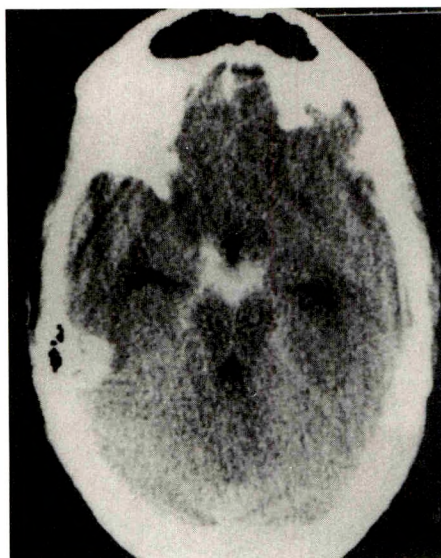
CT scan shows center of bleeding extending from interpeduncular fossa to left ambient cistern.
